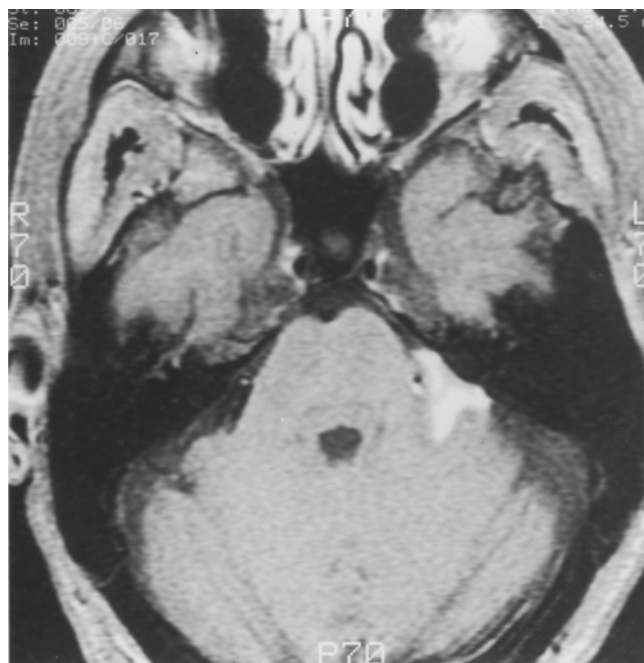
MRI T1-weighted image with gadolinium injection. A homogenous enhancing mass is noted in the left pontocerebellar angle with minimal edema around the tumor.
